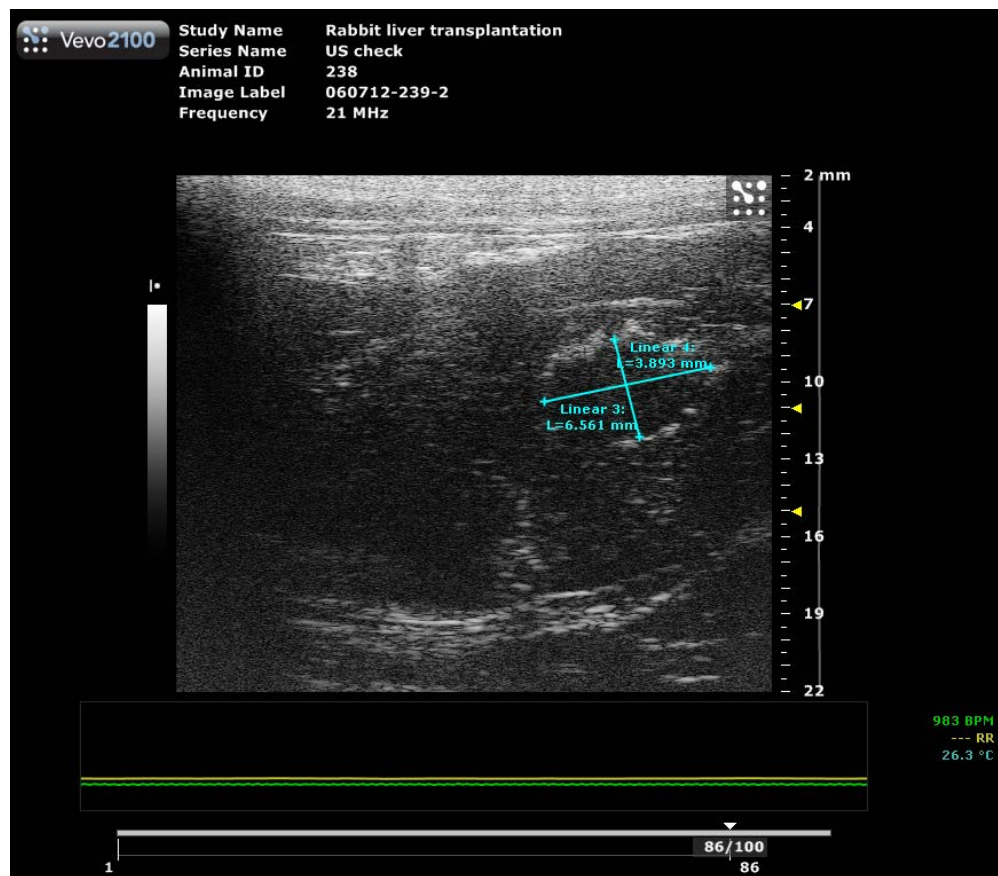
Ultrasound image of a single liver tumor in a recipient rabbit (B mode).
